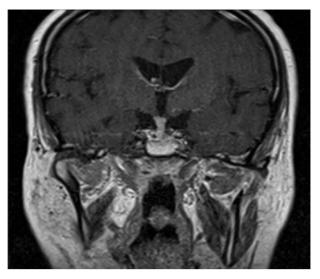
Brain magnetic resonance image: coronal post contrast T1 weighted image demonstrating abnormally thickened pituitary stalk.
